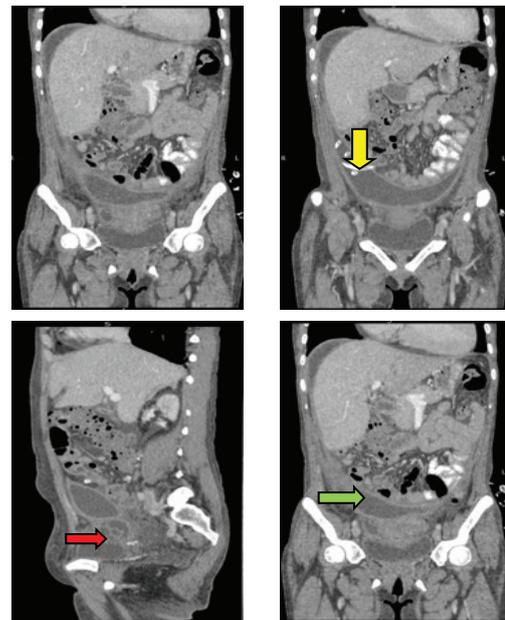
showed the abdominal computed tomography. Intra-abdominal collection (white arrow), Tenckhoff catheter (yellow arrow), hydrosalpinx (red arrow) and fistulous communication between hydrosalpinx and pelvis collection (green arrow).
